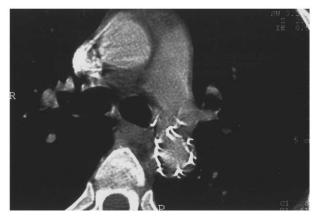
Computed tomography scan obtained at 6-month follow-up demonstrates complete healing of the aortic wall.
